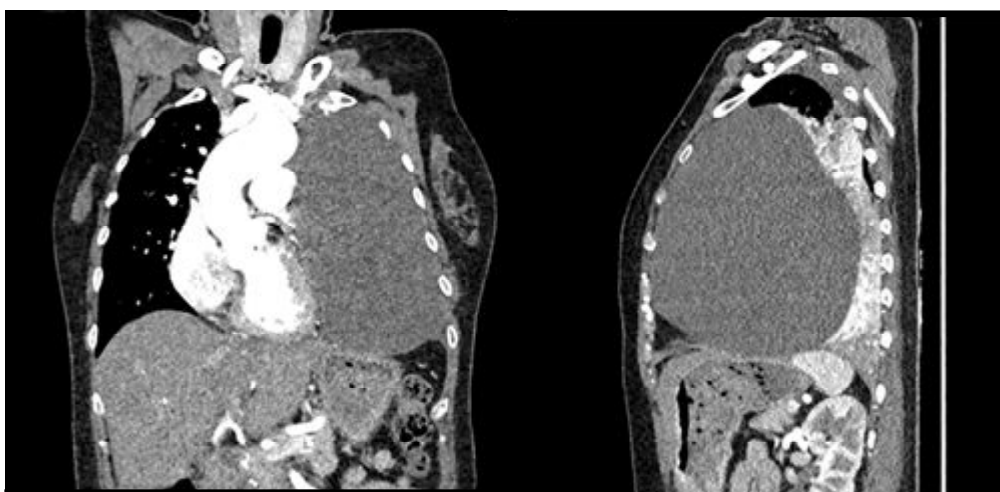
Coronal and sagittal plane of contrast chest CT showing cystic mass, round shaped, well defined margin, thin walled, with size $\pm 14.6 \times 9.1 \times 16.7$ cm in left hemithorax, suggesting from mediastinum anterior until posterior. CT, computed tomography.
